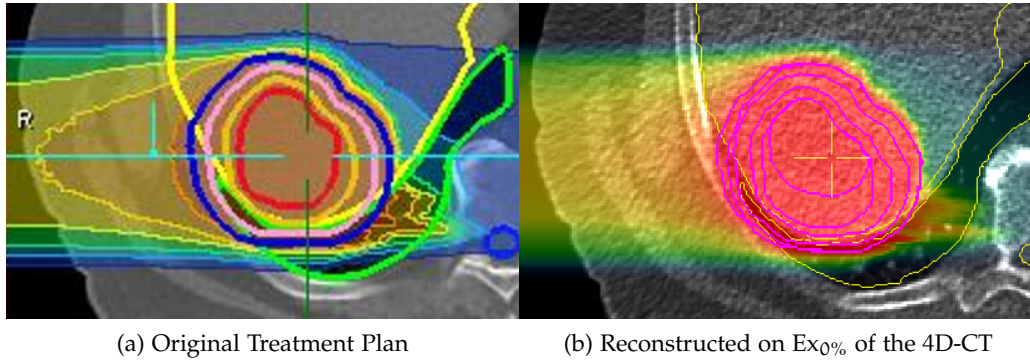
Re-Calculation on a 4D-CT: Original treatment plan calculated on the treatment planning CT in the *SyngoPT* treatment planning system, re-calculated dose on the Ex₀% phase of the 4D-CT using TRiP. This calculation can determine if the dose coverage is sufficient in all motion phases or if there is an increased dose to organs at risk, in this example the spinal cord.
